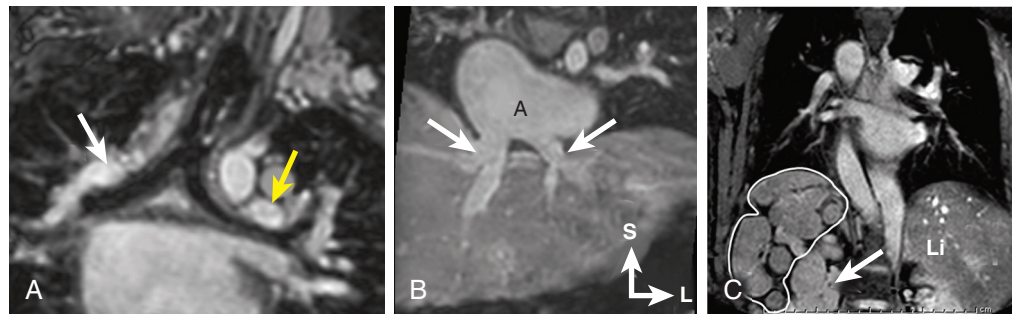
■ Coronal magnetic resonance images in patients with heterotaxy syndrome. A, Symmetrical hyparterial bronchi, both of left-sided morphology (long bronchi with the first branch some distance from the carina), in a patient with polysplenia syndrome. The right (white arrow) and left (yellow arrow) pulmonary arteries are above the ipsilateral bronchus. B, Symmetrical hepatic veins (arrows) draining separately into the common atrium (A) in the same patient with polysplenia. (Directional marker applies to all three images.) C, Multiple spleens (white outline) on the right side of the abdomen in a patient with right-sided polysplenia. In our autopsy series, right polysplenia is slightly more frequent than left polysplenia. The right kidney (white arrow) is seen medial and inferior to the spleens. The liver (Li) is left-sided. L, Left; S, superior.
